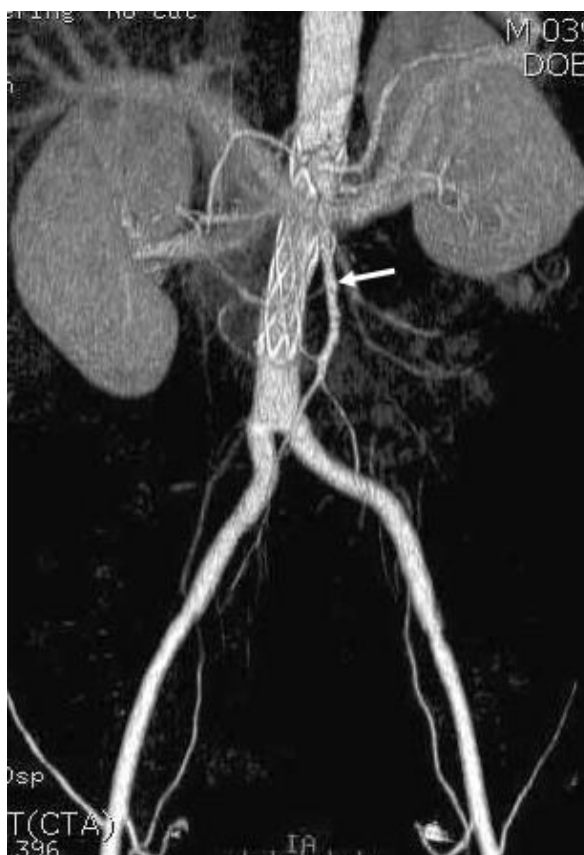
b. CTA shows a patent SMA(arrow) and both renal arteries.
